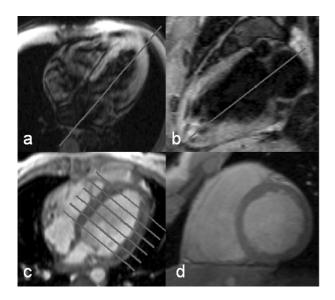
(a-b-c-d): MRI scout images; a) orientation of scan plane on axial view from mitral valve to cardiac apex to obtain longitudinal long axis view; b) Longitudinal long axis view is a scan plane for the horizontal long axis view (4 chambers view) from mitral valve to cardiac apex; c) Horizontal long axis view (cine FLASH 2D); orientation of the scan plane perpendicular to the long axis view to obtain contiguous short axis views (thickness 8 or 10 mm) from mitral valve to cardiac apex. d) Short axis view (cine FLASH 2D)
